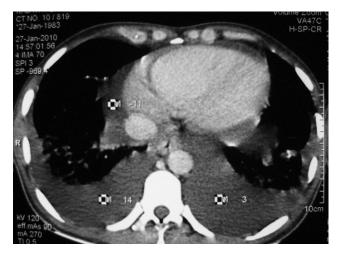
Computed tomography chest demonstrating polyserositis—bilateral pleural with pericardial effusion.
